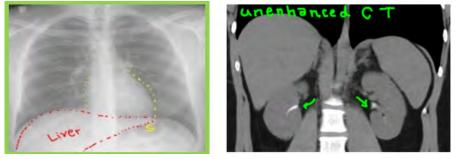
CT with no contrast showed stag horn calculi both kidnies
